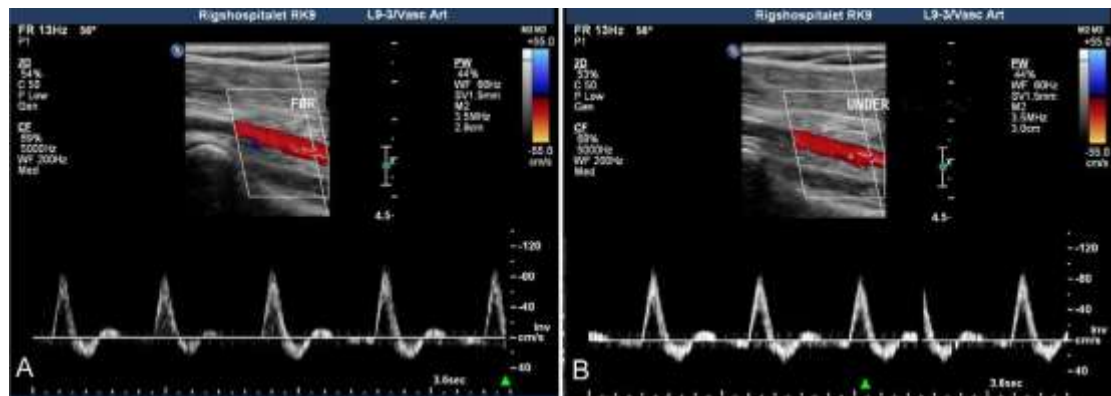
A, Duplex ultrasound scanning of the popliteal artery (in a healthy volunteer) in rest showing triphasic signal. B, Duplex ultrasound scanning of the popliteal artery (in the same participant as in [A]) during plantar flexion test showing unchanged normal flow pattern and unchanged max velocity ⁽²⁾
